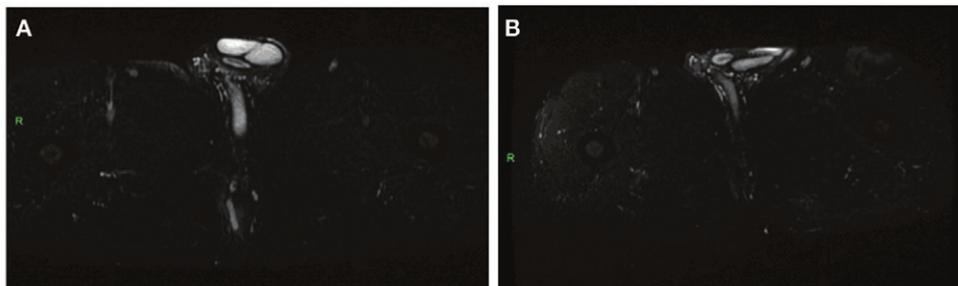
Clinical case example of a combined remission patient. Pre-operative (A) and 6.5 years after surgery (B) magnetic resonance imaging.
